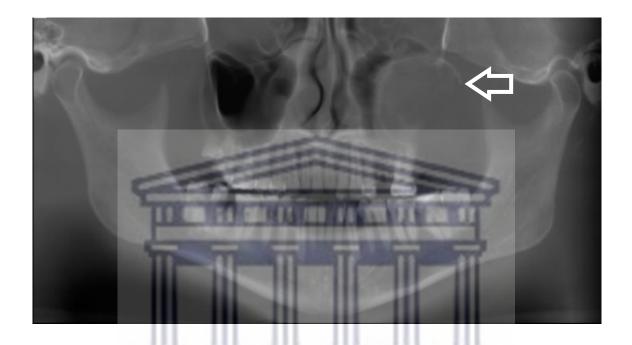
Pre-operative pantomograph reconstruction of cone beam computed tomography (CBCT) of large residual cyst in the left maxilla extending into maxillary sinus.
